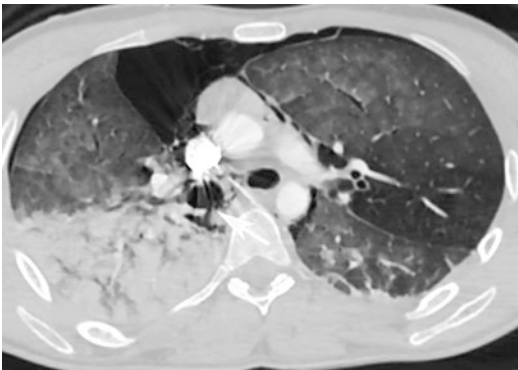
Post-contrast axial CT scan depicts the disruption of the right main-stem bronchus with a visible posterior wall defect (*white arrow*). There is a bilateral pneumothorax associated with lung contusions and parenchymal haemorrhage of the right inferior lobe due to a diffuse laceration
